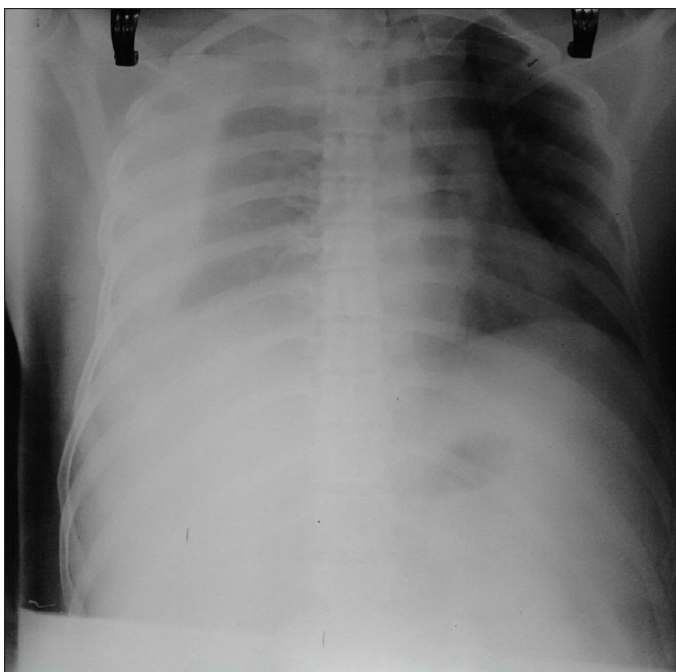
Chest X-ray, hemothorax
